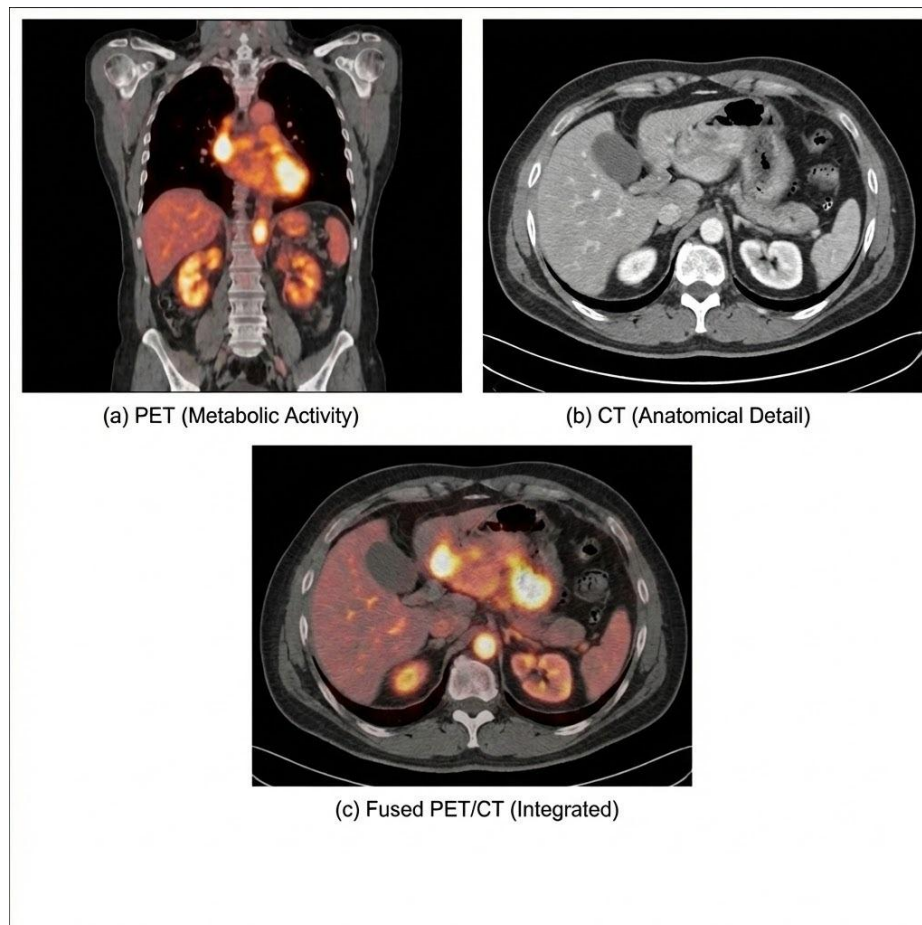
Example of multimodal imaging combining PET, CT, and fused PET/CT images. The PET image (a) shows metabolic activity based on radiotracer uptake, the CT image (b) provides anatomical detail, and the fused PET/CT image (c) integrates both datasets, allowing precise localization of functional abnormalities within anatomical structures. (Image generated using artificial intelligence).
